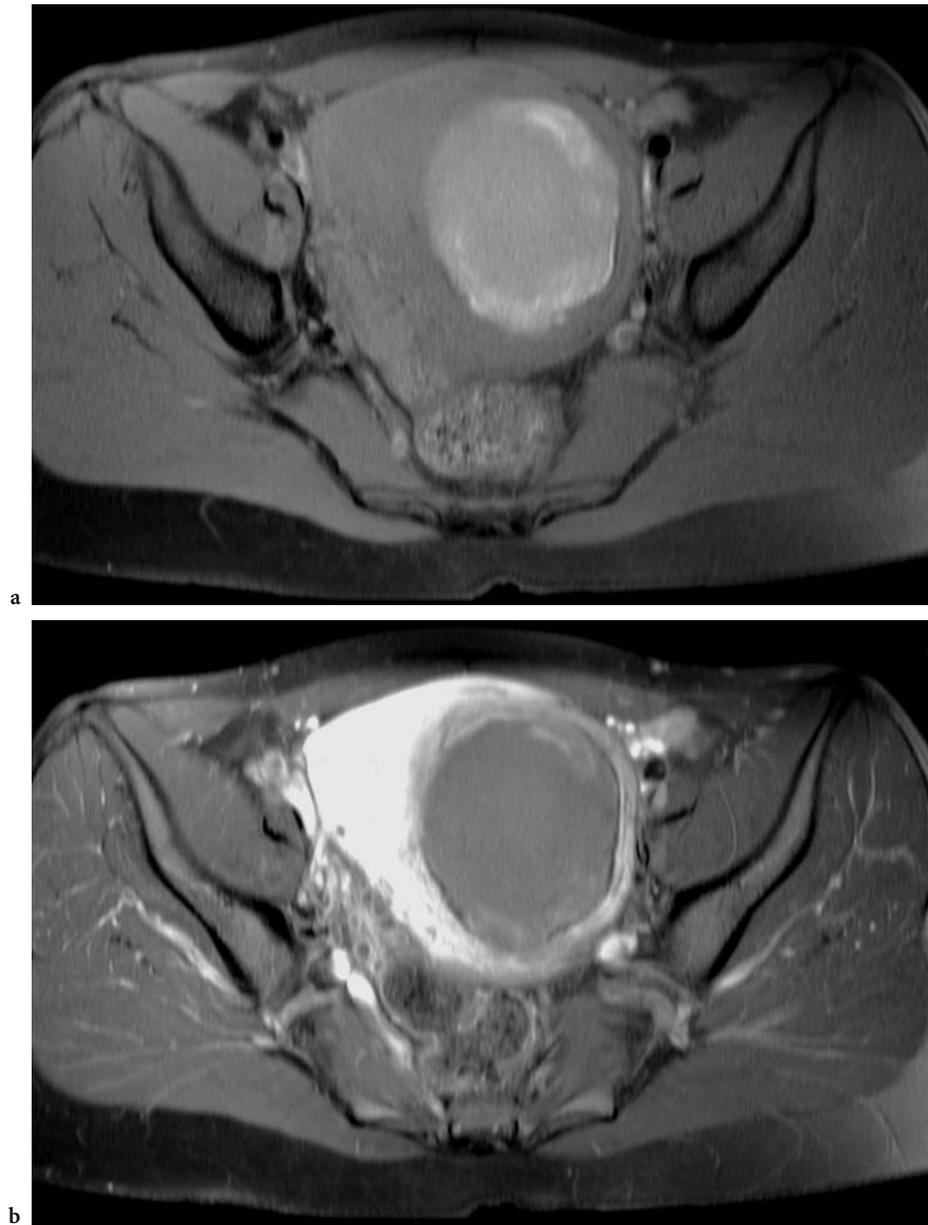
MRI of hemorrhagic leiomyoma infarction: “bag-of-blood-sign”. a Transaxial T1-weighted fat-suppressed image obtained 3 months after UAE. Peripherally accentuated hyperintense signal intensity of the leiomyoma indicating hemorrhagic transformation of the leiomyoma (“bag-of-blood-sign”). b Transaxial contrast-enhanced T1-weighted fat-suppressed image obtained 3 months after UAE. Lack of enhancement of the leiomyoma consistent with infarction. (Reproduced with permission from [223])
